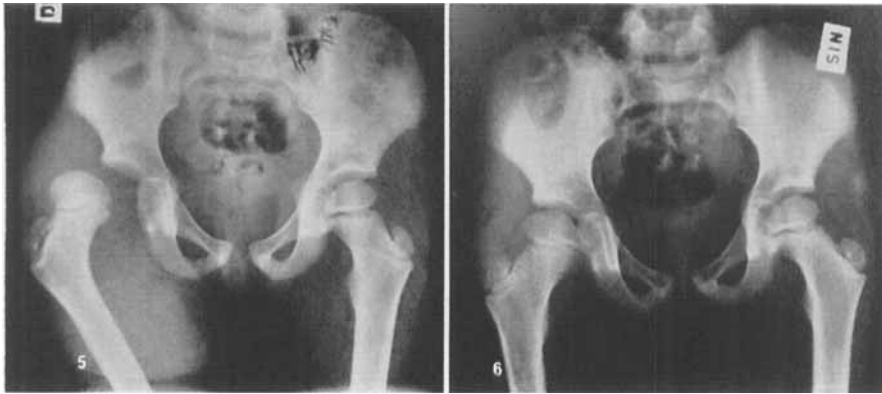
Radiograph on the right hip of the girl at the age of 5 years during provocation test.
